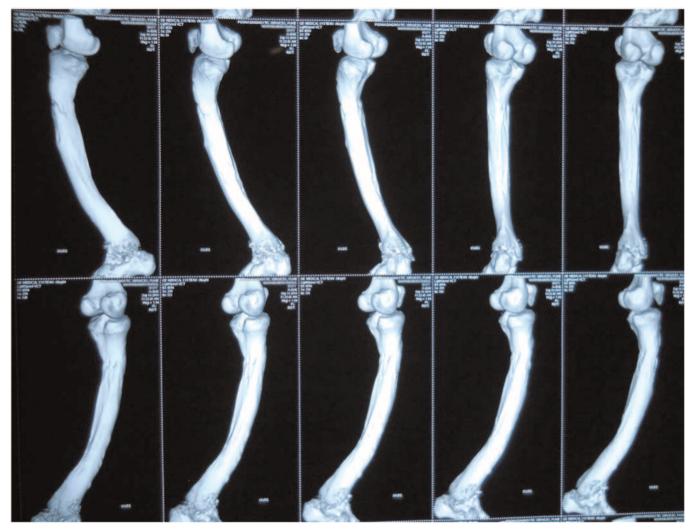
CT scan at 1-year after surgery (three-dimensional reconstructions).
